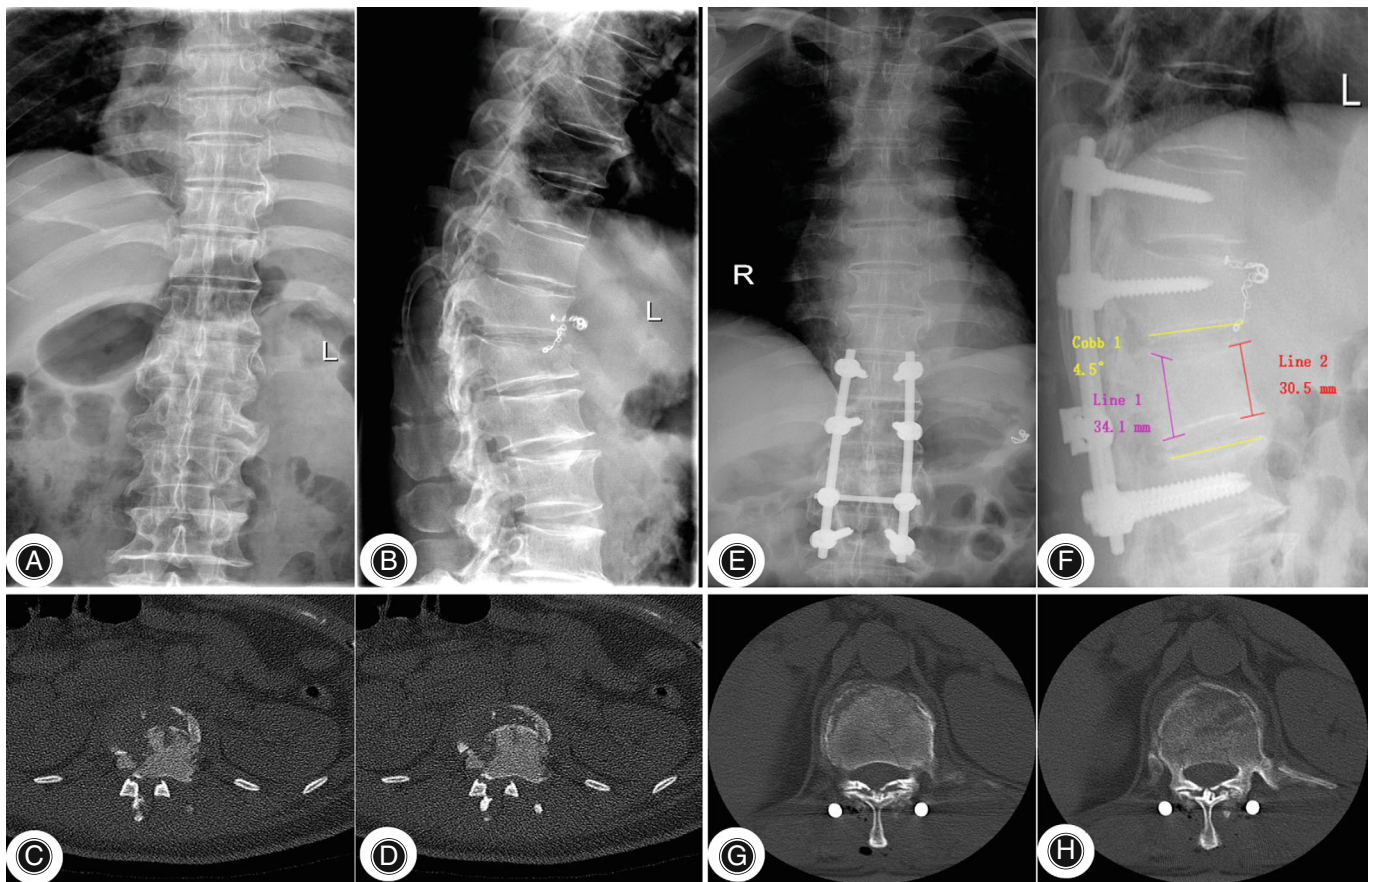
A 46-year-old man had a burst fracture of the 2nd and 3rd lumbar vertebrae with a TLICS score of 6 points (Cobb angle: 4.5° , Anterior vertebral losing height of fractured vertebra = line 2 / line 1 = 0.89). Preoperative imaging examinations of anteroposterior and lateral (A, B) radiographs, CT (C, D) showed that the fracture fragment intruding into the spinal canal leading to spinal stenosis. The patients were followed up for 6 years after posterior lumbar 2 and 3 vertebral fractures were decompressed by translaminal window and lumbar 3 vertebral graft vertebroplasty. Anteroposterior and lateral radiographs (E, F), CT (G, H) were reviewed. TLICS, thoracolumbar injury classification and severity score; CT, computerized tomography.
